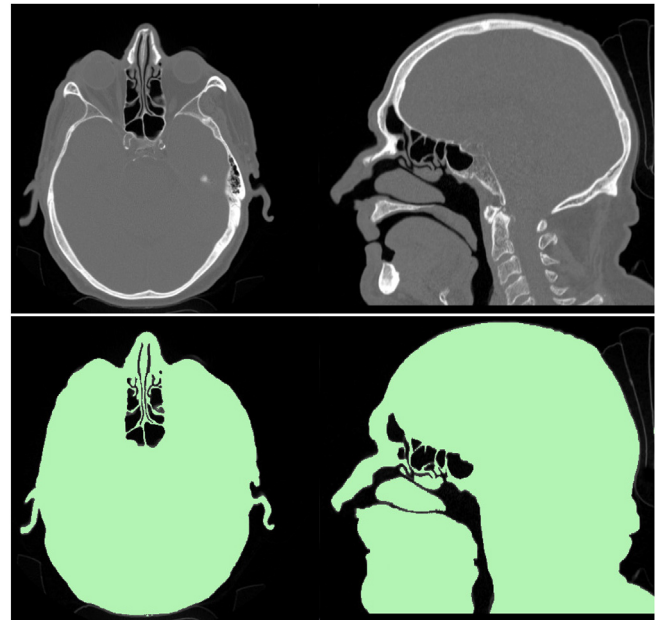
Representative CT images (top) and their segmentation obtained with a threshold value of  $HU = -218$  (bottom), after removal of the connection between epiglottis and mouth. Black regions correspond to the air-filled volume.
